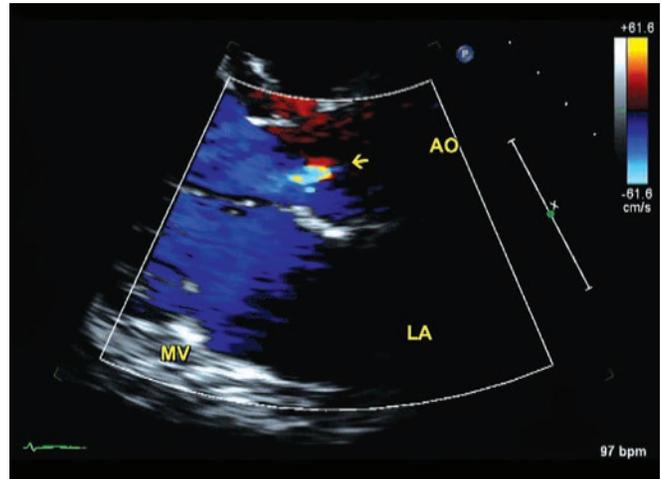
Transthoracic parasternal long axis view. Arrow points to aortic regurgitation.
